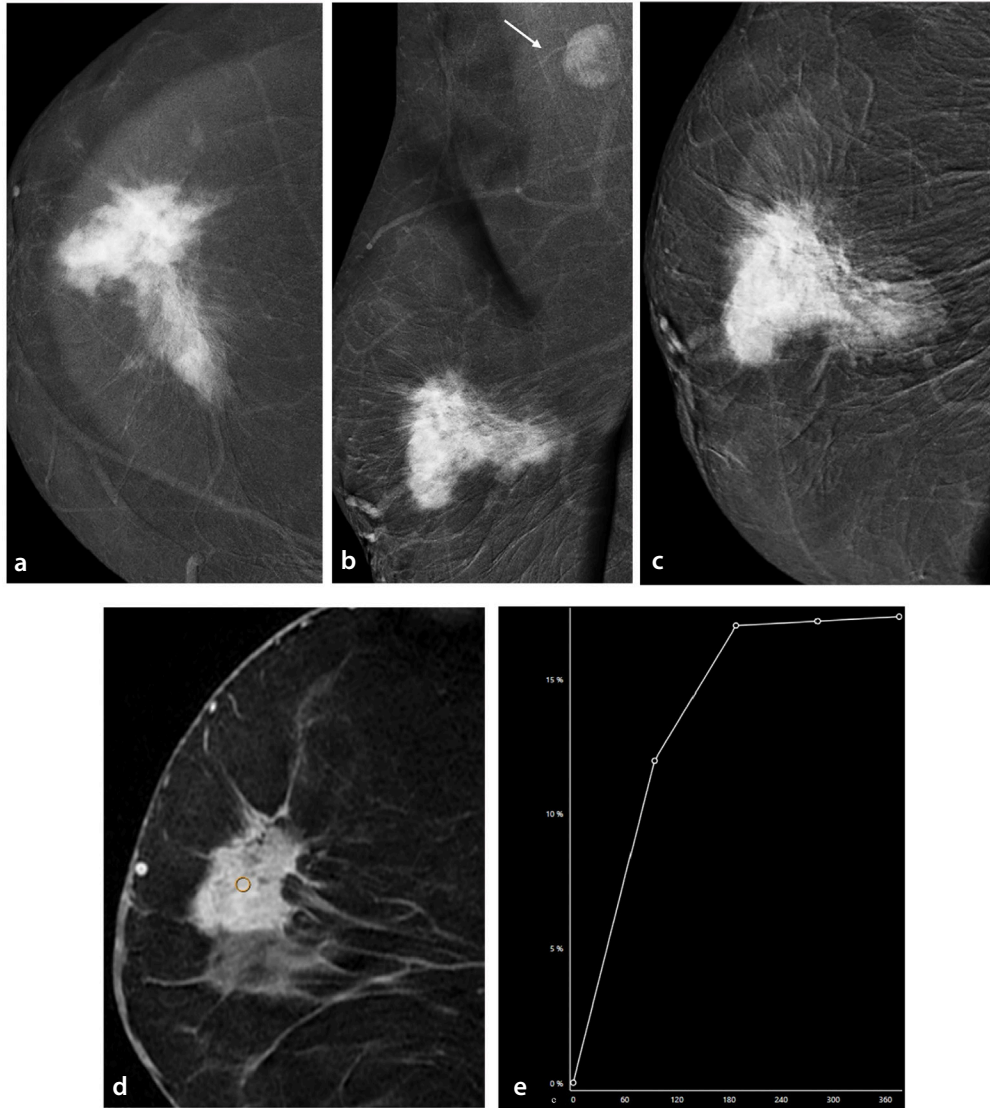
An American College of Radiology Breast Imaging Reporting and Data System 5 mass in the right breast at the 12 o'clock periareolar region demonstrates spiculated margins, high conspicuity, parenchymal distortion, nipple retraction, and tethering of the Cooper ligaments on contrast-enhanced mammography (CEM). The lesion exhibits intense enhancement without definite washout on the 4-minute delayed phase image (a–c). Correspondingly, breast magnetic resonance imaging reveals an irregular mass with a type 2 kinetic curve in the same location (d, e). A right axillary lymph node with cortical thickening is visualized on CEM (b).
